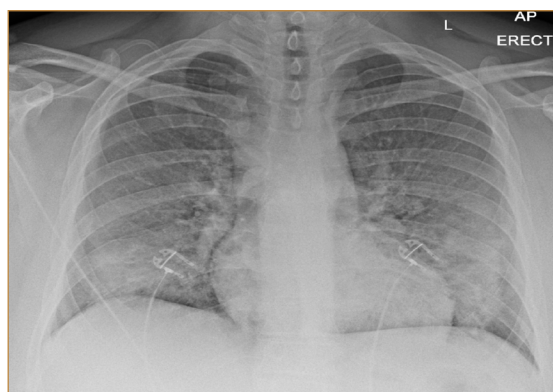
X-ray chest showing bilateral interstitial infiltrates
